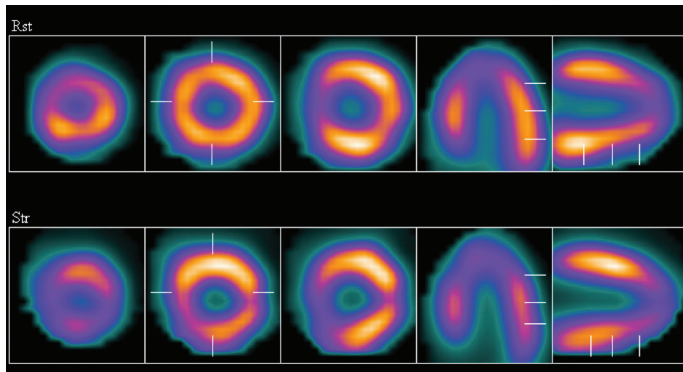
Apicolateral ischemia in myocardial perfusion scintigraphy.
